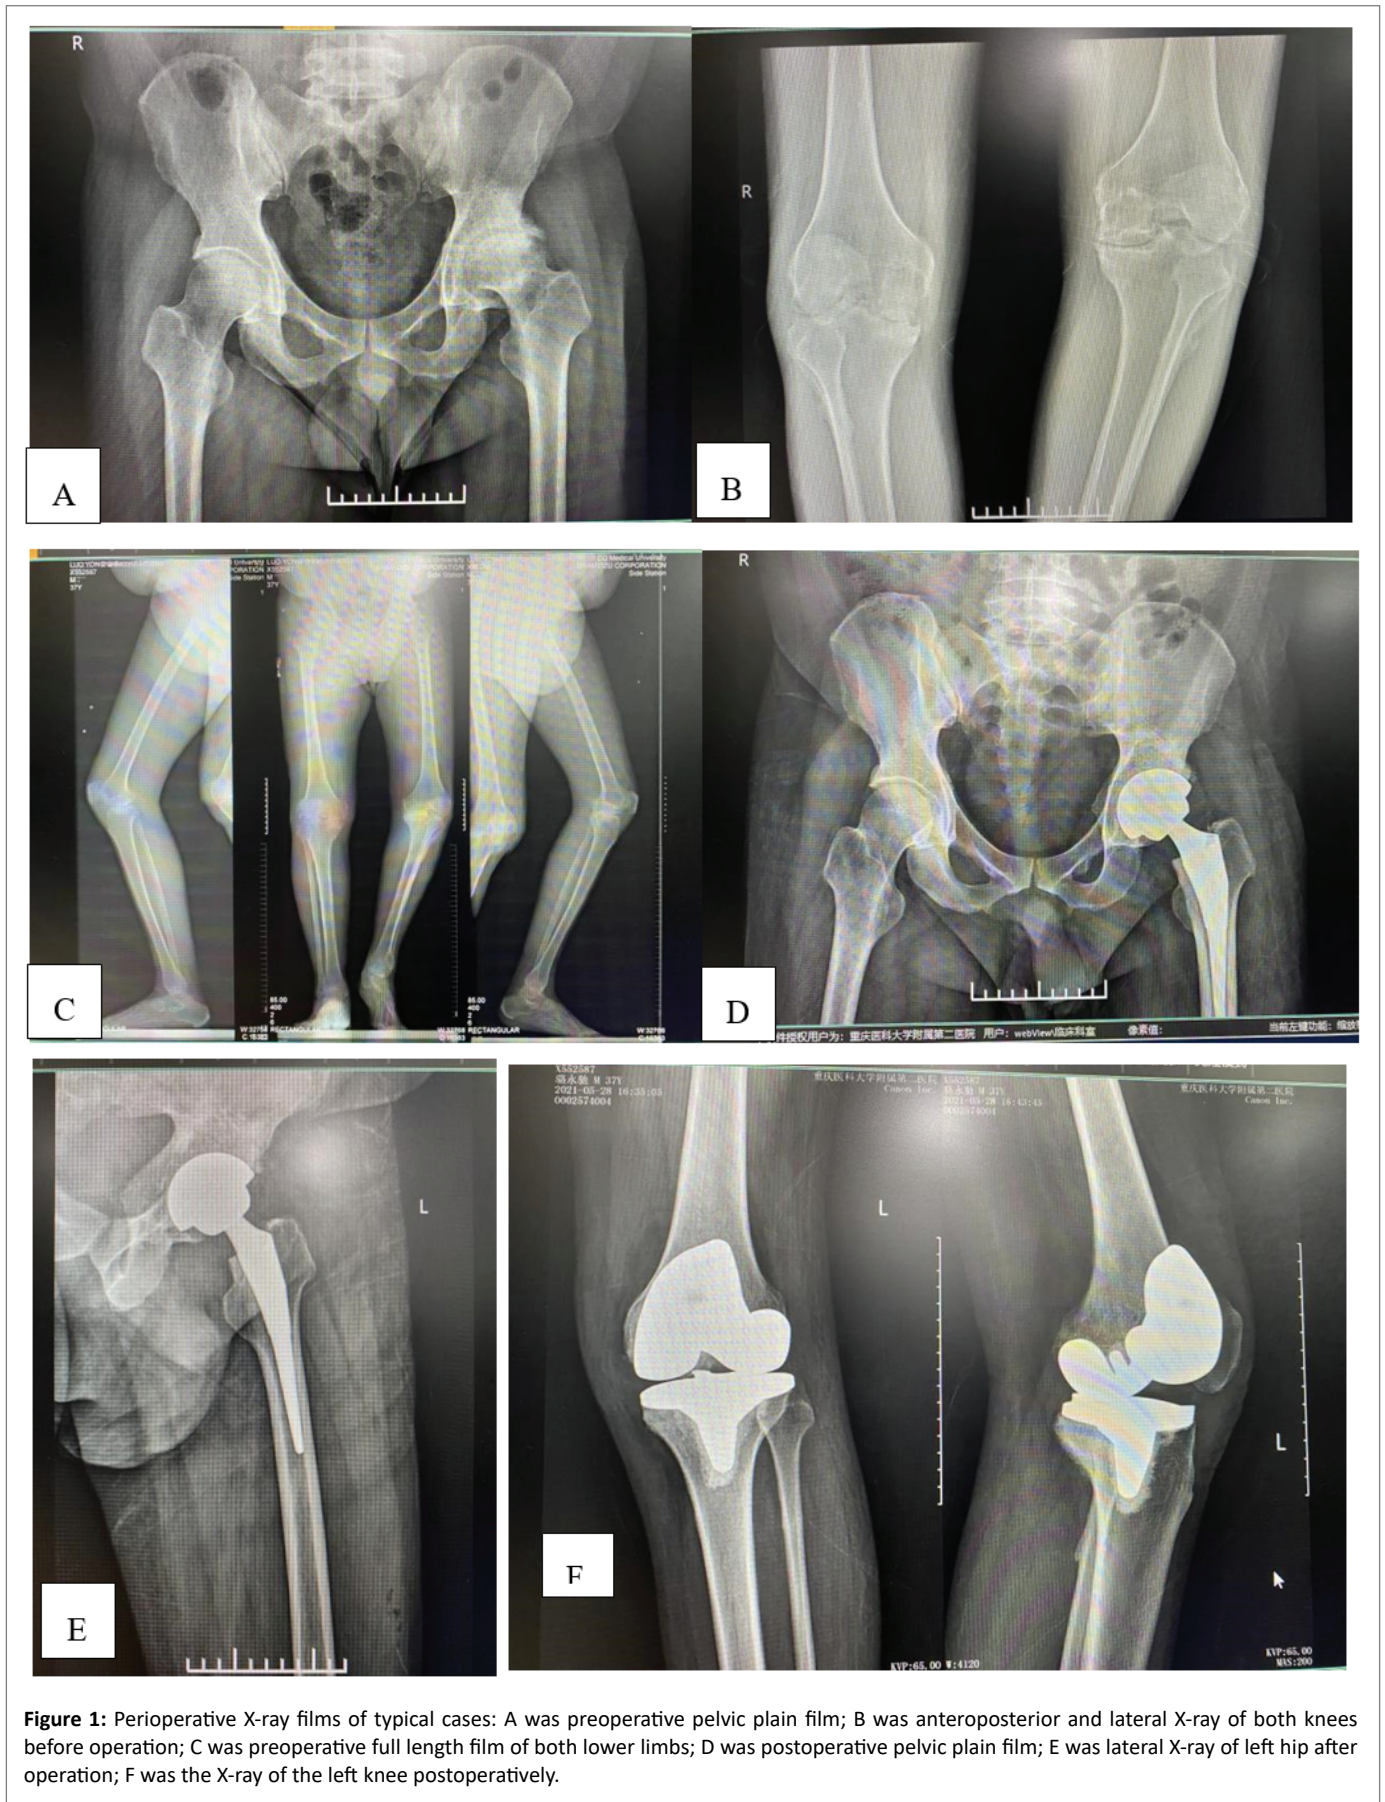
Perioperative X-ray films of typical cases: A was preoperative pelvic plain film; B was anteroposterior and lateral X-ray of both knees before operation; C was preoperative full length film of both lower limbs; D was postoperative pelvic plain film; E was lateral X-ray of left hip after operation; F was the X-ray of the left knee postoperatively.
